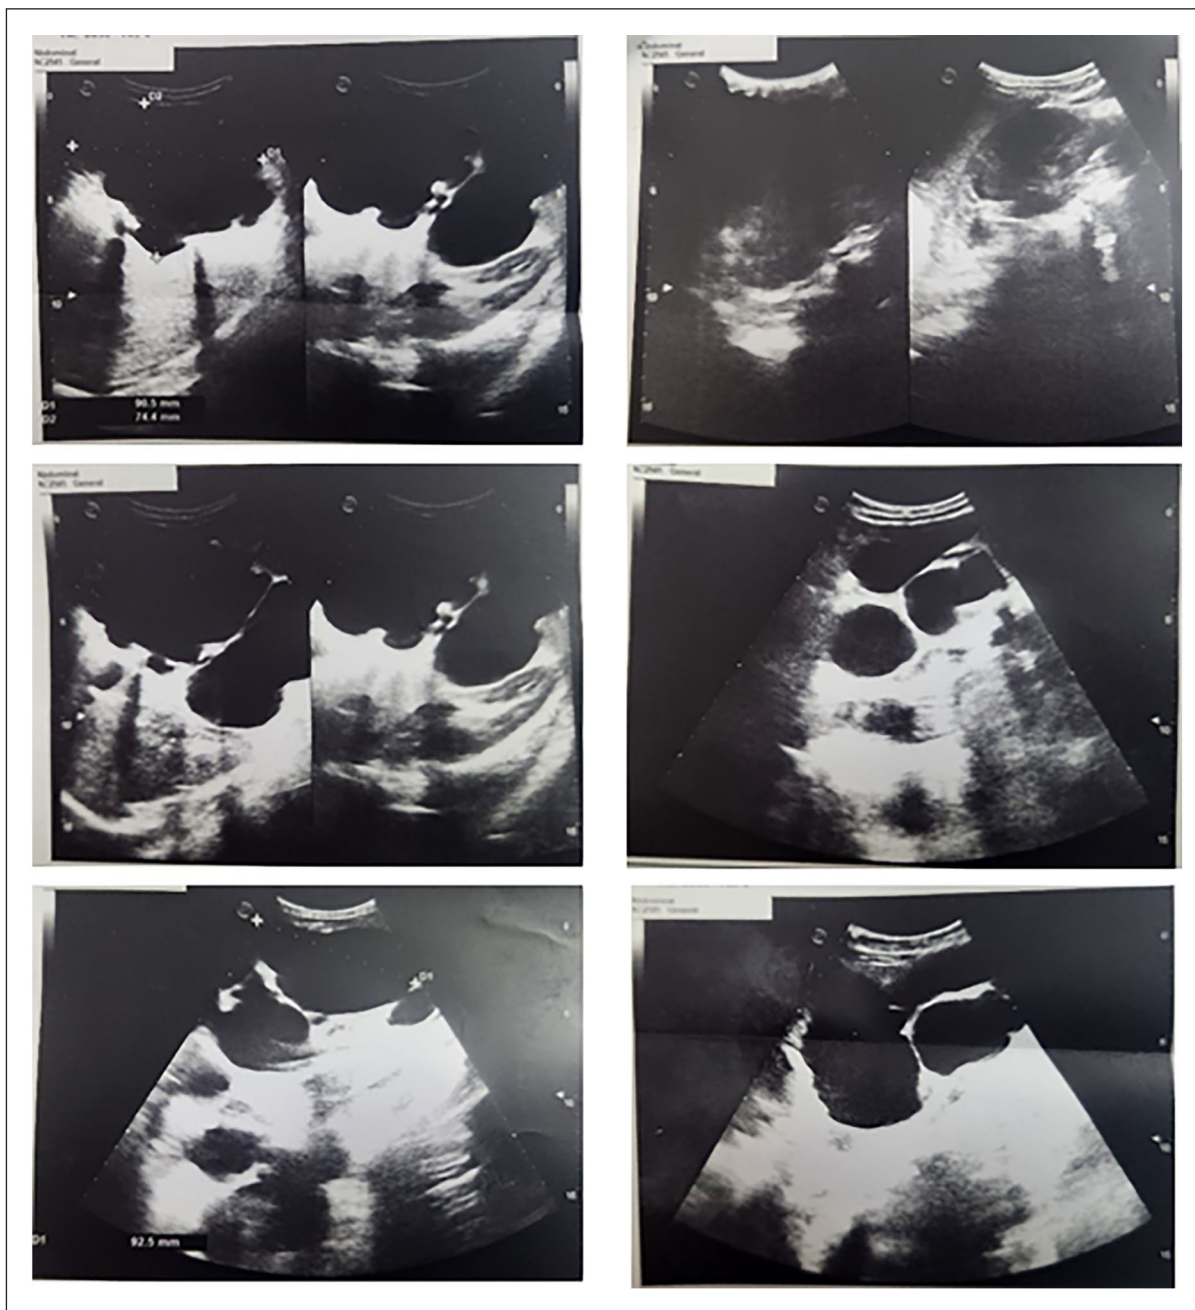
Ultrasound demonstrated a multicavity formation of cystic masses within the abdominal cavity behind the umbilicus, all interconnected and extending upwards below the epigastrium and downwards to the bladder with entry into the pelvis and extension to the flanks. There are no solid masses or abnormalities of the cyst walls detected. However, a thickened cyst wall is observed in some regions, accompanied by focal calcifications.
